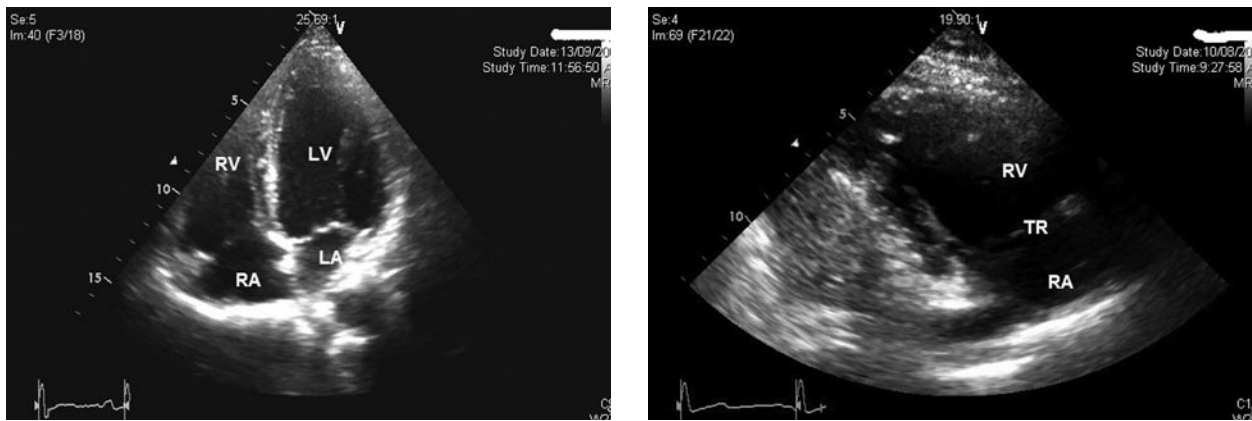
The right ventricular masses disappeared A: 4 chambers view. B: left parasternal view (RV inflow)
